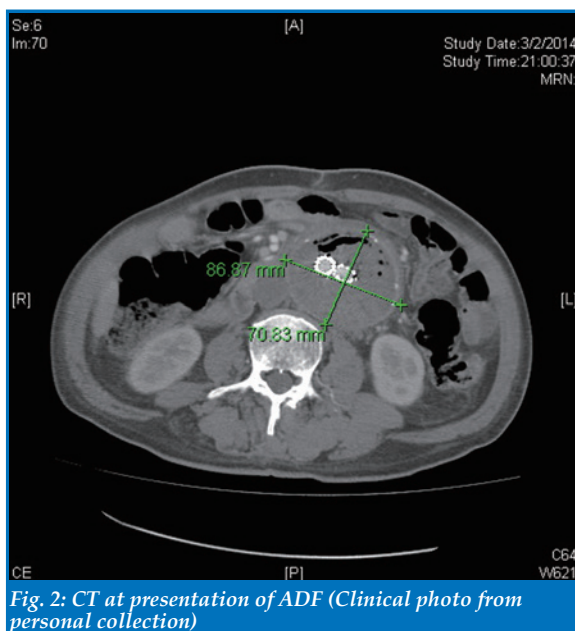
CT at presentation of ADF (Clinical photo from personal collection)
